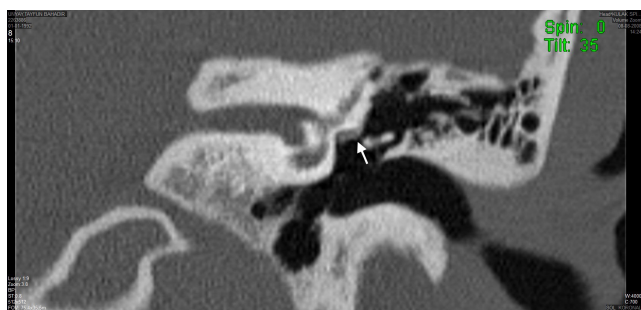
Left coronal computed tomography showing the facial nerve over the oval window (White arrow).
